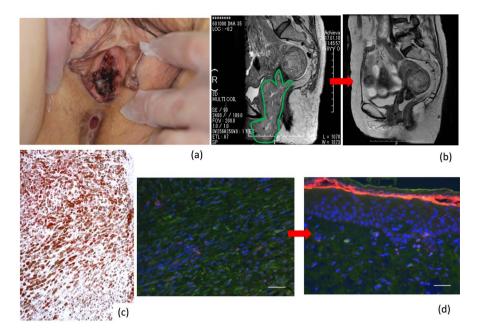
(a) Clinical feature of the genital lesion. An irregular black macule was observed on the bilateral major labia to the vagina; (b) MRI showed the complete disappearance of the massive tumor after the 15th cycle of nivolumab and radiotherapy; (c) Dense infiltration of melanophages positive for CD68 was noted without melanoma cells; (d) Greater infiltration of CD8⁺PD-1⁺T cells to the lesional skin was noted after treatment than before treatment.
